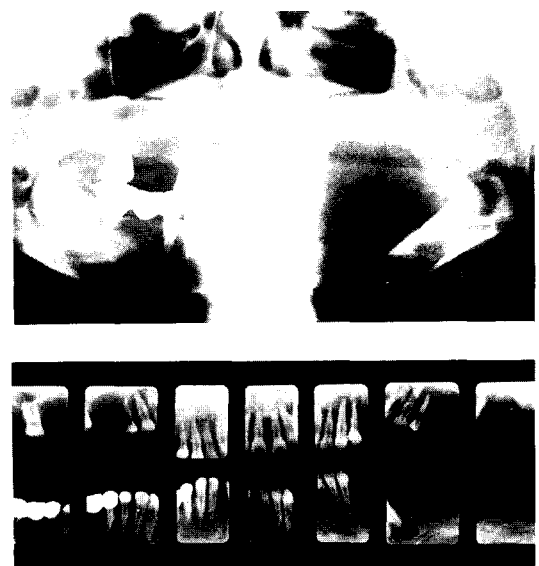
Panoramic(A) and periapical radiographs(B) demonstrating regeneration of alveolar lamina dura and trabeculae.
